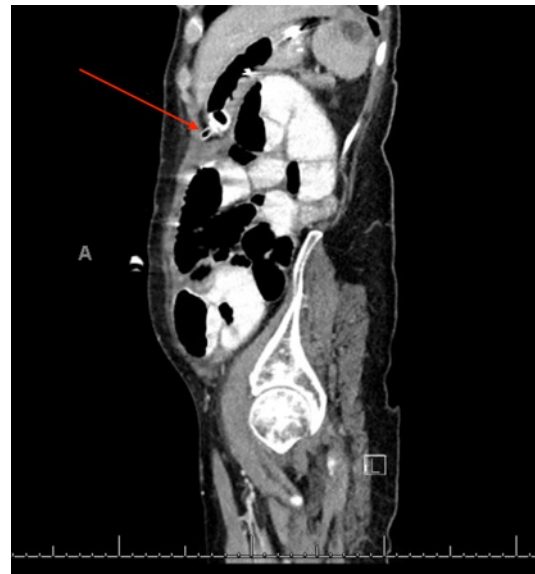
Sagittal CT showing the steep angle (red arrow) required to access the stomach for hybrid gastrostomy.
